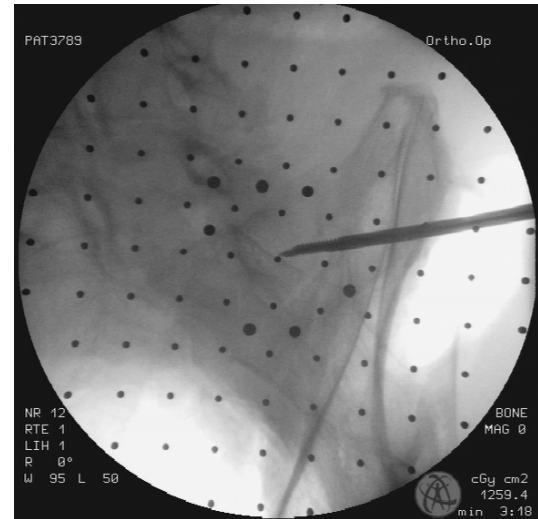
Second X-ray image during registration
